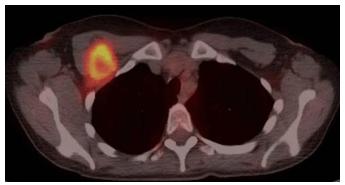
Axial PET-CT showing intense radio tracer uptake (SUV 9.6) within the mass.
